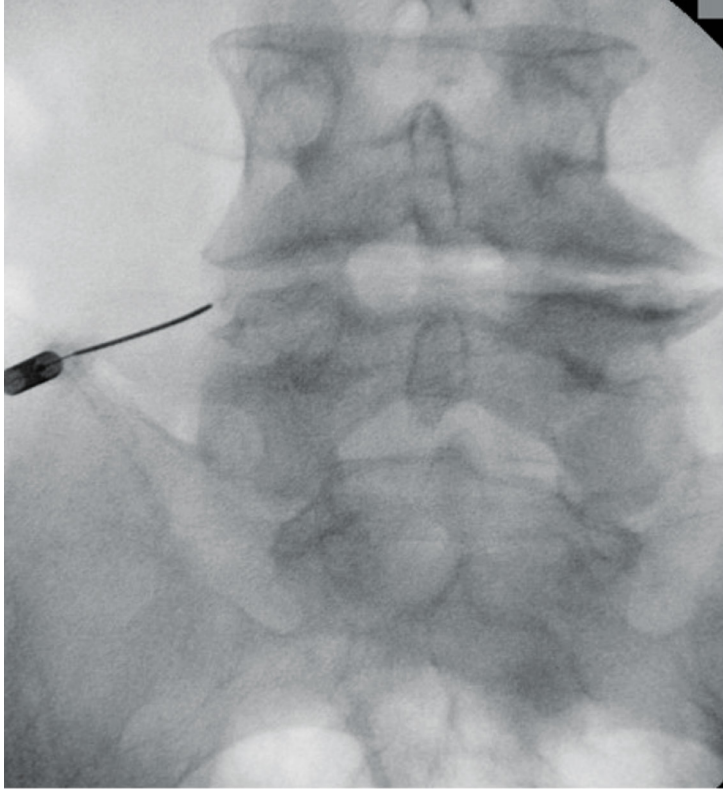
A-P X-ray of the electrode placed on left transverse process of L5
